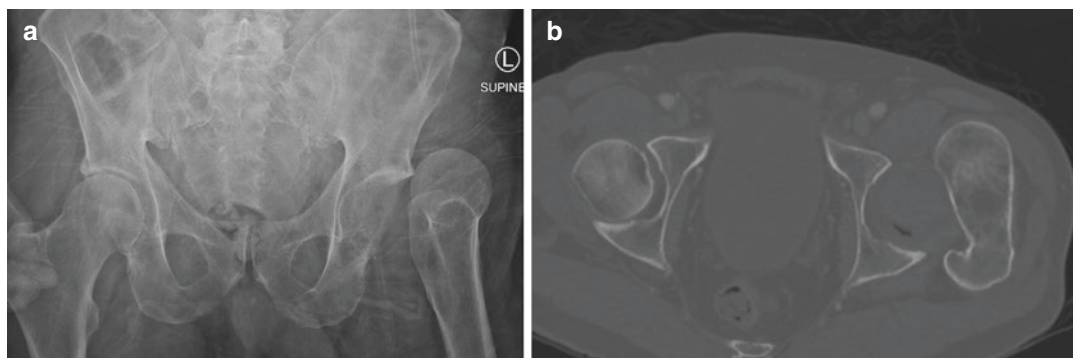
(a) AP radiograph of an anterior hip dislocation at presentation. (b) CT scan of the same case, showing the direction of dislocation more clearly
